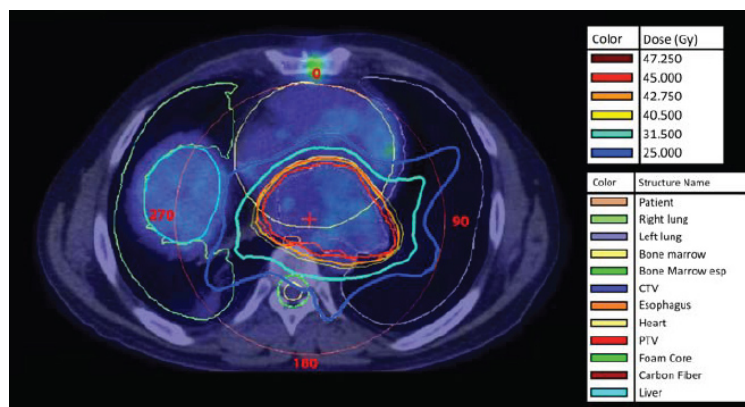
18F-FDG PET/CT transaxial fused image was used to overlap the isodose curves of the radiotherapy plan as a further comparison evaluation of the irradiation distribution and showed matching of target volumes.
